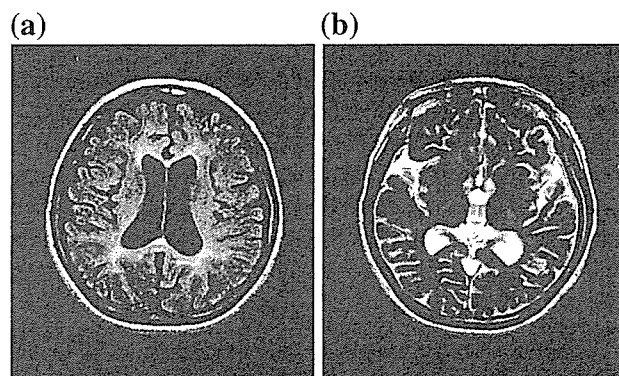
Brain MRI. (a) High intensity lesions in the bilateral periventricular white matter on an axial FLAIR image (TR: 8000 ms, TE: 120 ms). (b) Low intensity lesions in the bilateral basal ganglia on an axial T2-weighted image (TR: 4000 ms, TE: 102 ms).
